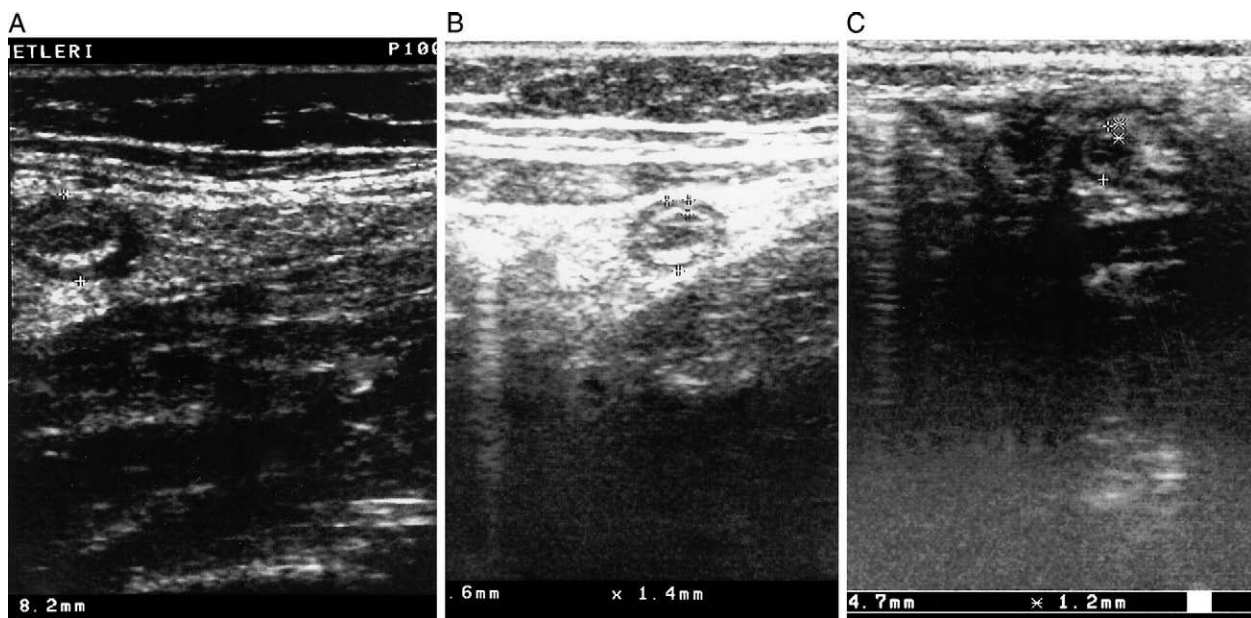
Ultrasound images, which show transverse diameters of the appendix before (A) and after (B, C) treatment.
